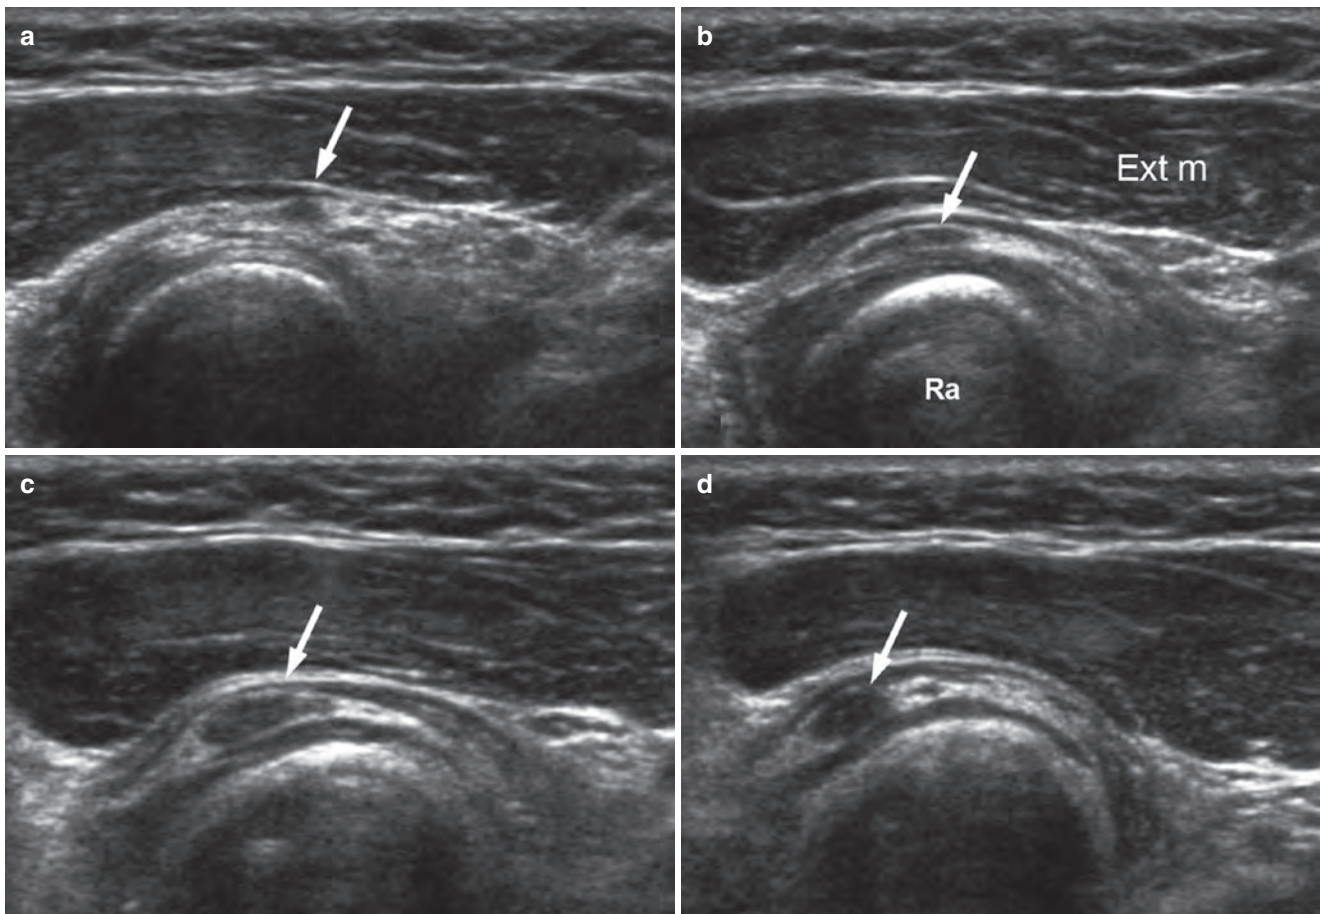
Series of transverse ultrasound images showing posterior interosseous nerve (arrows) (a) proximal to and (b–d) within the supinator tunnel of a 9-year-old boy with quite abrupt onset of weakness of finger extension. The PIN is swollen within the supinator muscle (‘supinator tunnel’) located between the radial neck and the extensor forearm
